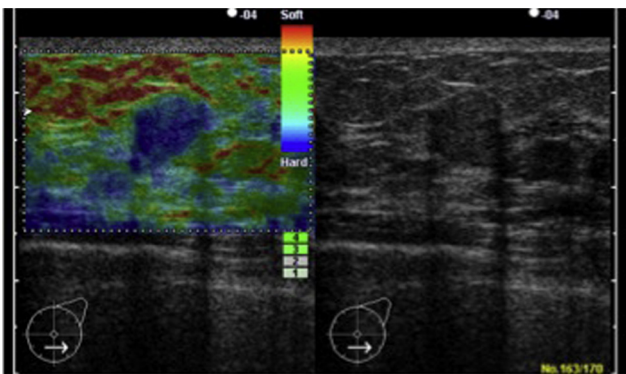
45-year-old, infiltrative ductal carcinoma. Free-hand elastography and B mode ultrasound (Hitachi®). The elastogram is homogeneously blue, indicating a poorly deformable lesion. However adjacent tissue is not blue and the Ueno score is 4, indicating a suspicious lesion requiring a biopsy, with irregular margins. Acknowledgement: Dr Anne Tardivon, Curie Institute, Paris.
